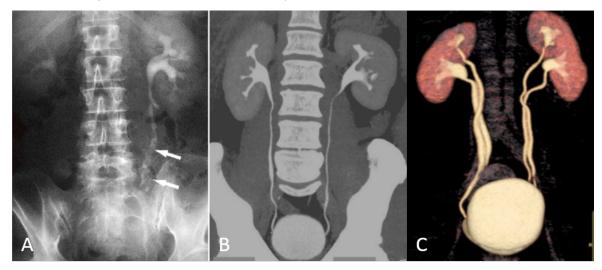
IVU: multiple filling defects in left ureter (A). CT-IVU with Maximum Intensity Projection (B) and 3D image reconstruction (C).
